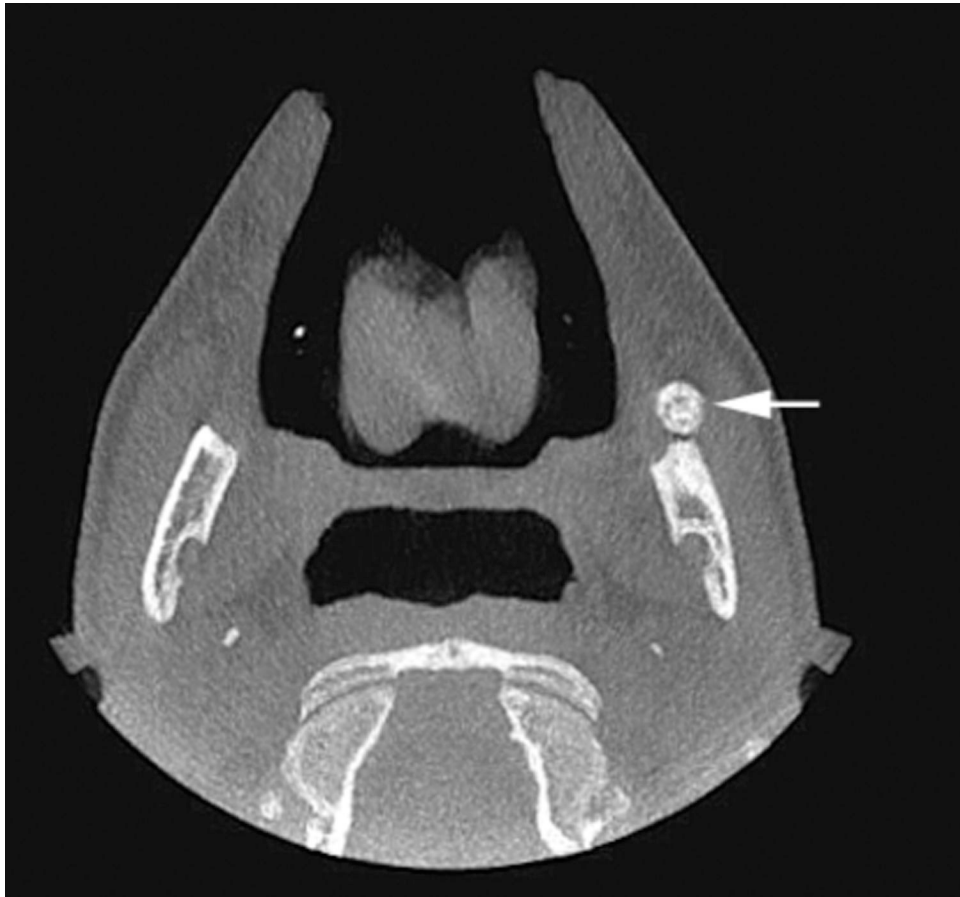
The axial view of the cone beam computer tomographic scan demonstrates a well defined radioopaque mass within the buccinator muscle anterior to the left mandibular ramus. This mass reveals zonation organization characterized by peripheral ossification and a focal central lucency.
